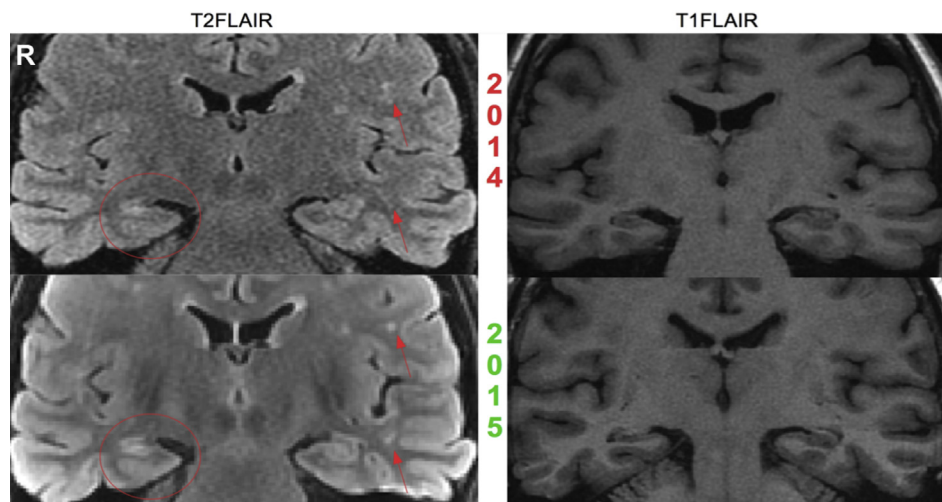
Patient 22: right HS and Small-Vessel Disease. In 2014 this patient received a dedicated epilepsy protocol at our center. Although the T1-FLAIR coronal sequence shows a comparable quality relative to the most recent 2015 T1-FLAIR, Small Vessel Disease and right HS were not detected by the neuroradiologist. HS and WM lesions related to small vessel disease are increasingly conspicuous on the most recent T2-FLAIR image relative to the 2014 T2-FLAIR image, the latter of which suffers from lower SNR. R = right.
